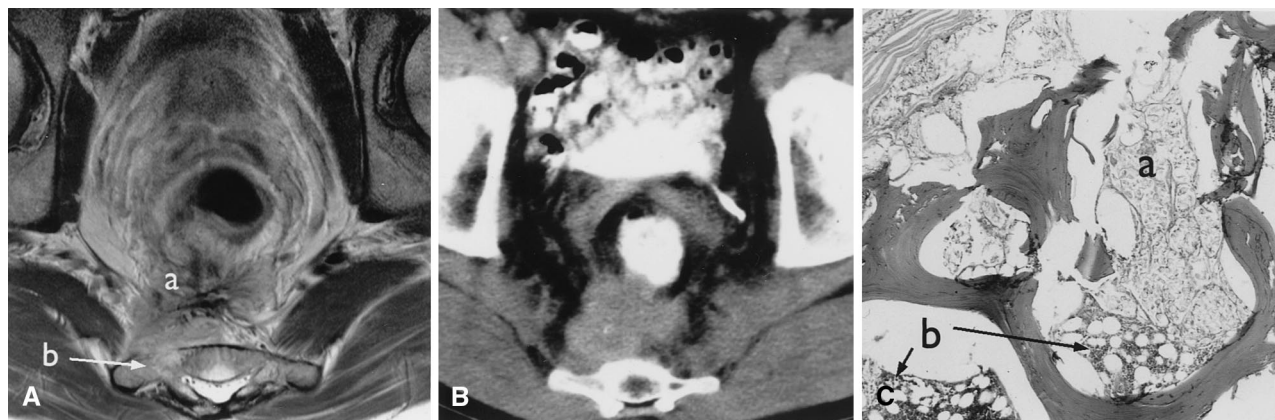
A 48-year-old male with recurrent rectal cancer in the presacral region. A Axial T2W TSE MRI shows the tumor (*a*) invading the bone marrow (*b*). B Axial CT at the level of the tumor fails to show bone marrow invasion. The axial CT section may appear to be at a different level
